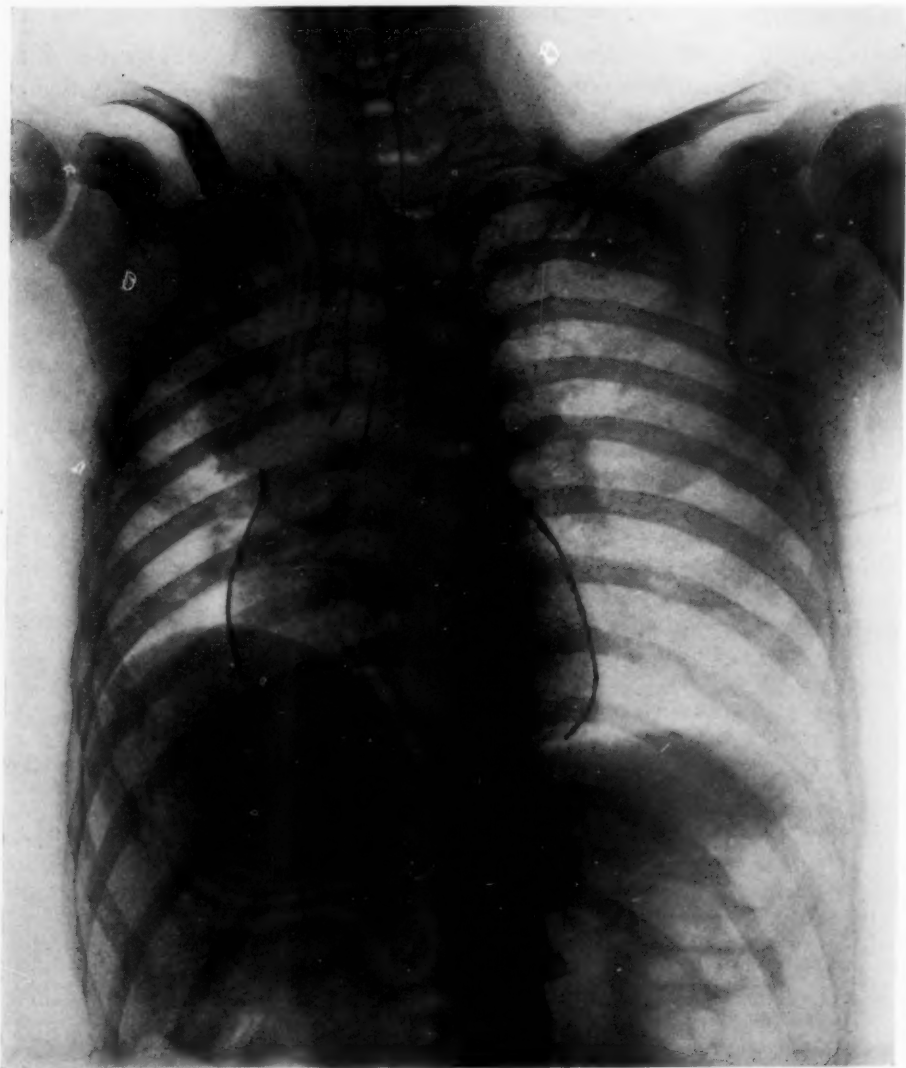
Roentgenograph taken at noon, December 28, showing a marked deviation of the trachea and heart to the right, elevation of the right diaphragm and a shadow of increased density in the upper right lung field. Temperature 103° F., pulse 130, respiration 40.
